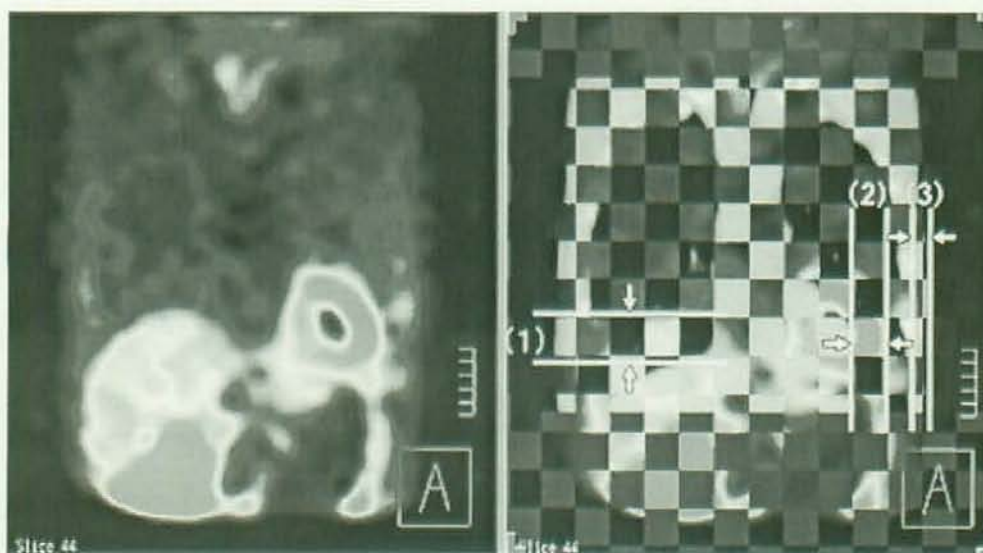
Coronal fusion image for measurement of the distances between the following reference points of both SPECT and CT images: (1) diaphragmatic dome, (2) heart border, (3) chest wall border.
